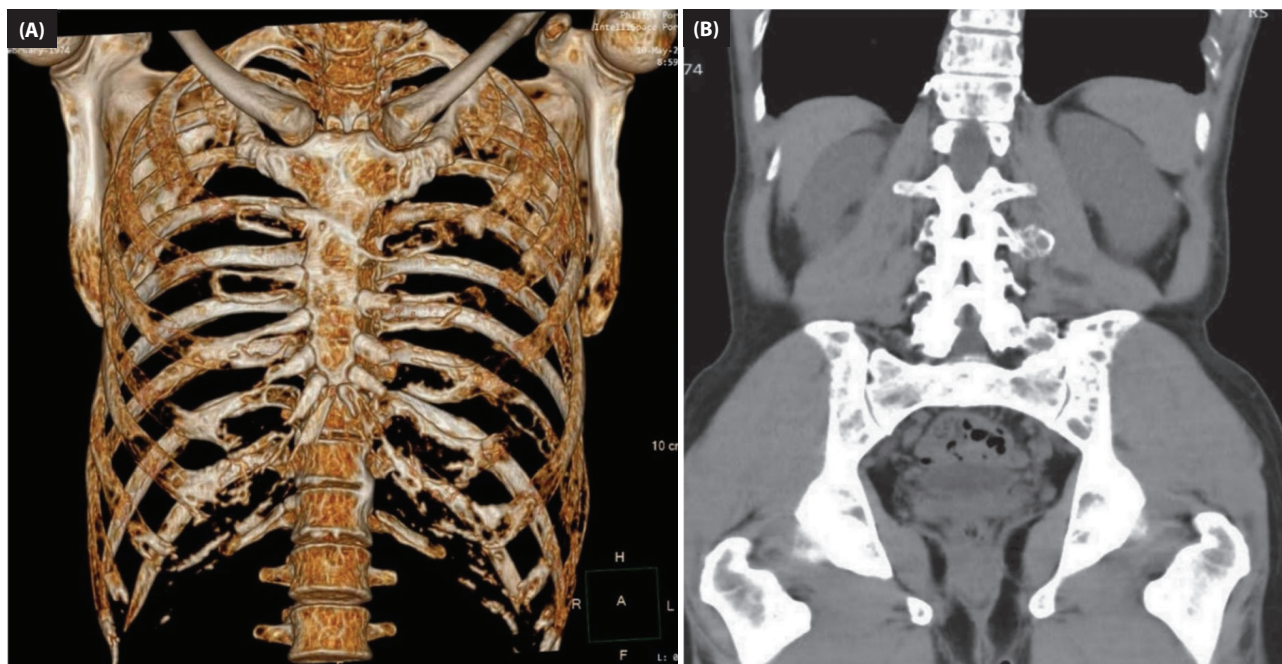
Computed tomography (CT) scan images showing multiple bone lesions. (A) Chest CT without contrast (3D reconstruction) demonstrates multiple lytic bone lesions involving the bilateral scapula, sternum, ribs, and spine (lower cervical, thoracic, and proximal lumbar regions). (B) Abdominal CT scan reveals multiple lytic bone lesions and osteopenia affecting the lumbosacral spine and pelvic bones.
